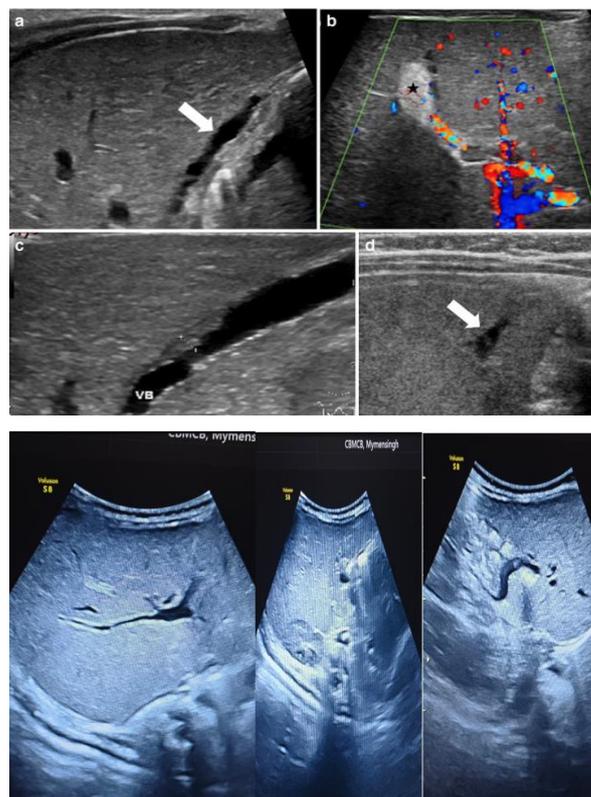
Ultrasonography findings of Biliary atresia in a neonate.
